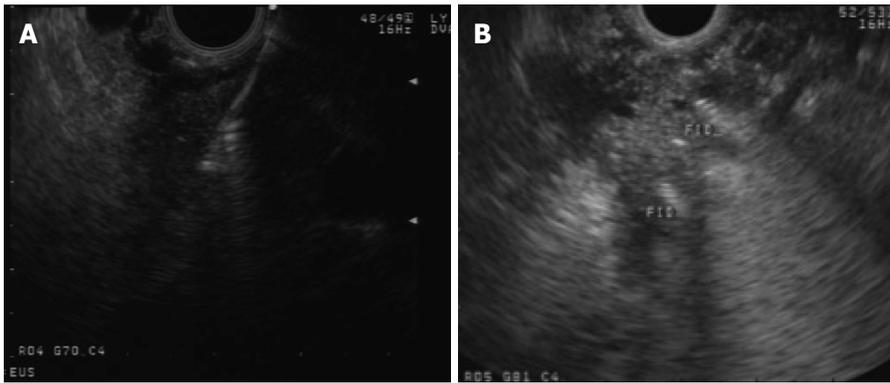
Endoscopic ultrasound guided deployment (A) and view (B) of fiducials in a pancreatic head mass.
